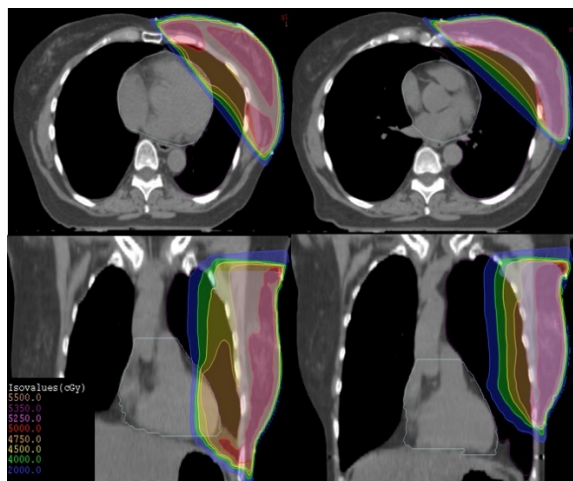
Axial and coronal CT slices of FB (on the left side) and DIBH (on the right side) dose distributions for the same patient.
